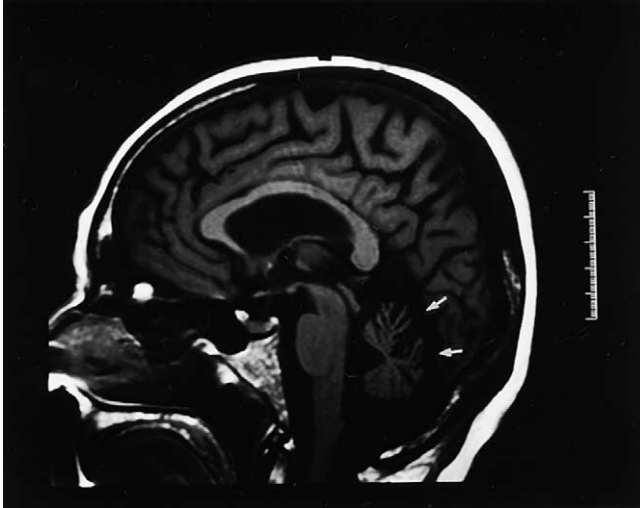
Sagittal T1-weighted MRI of the brain showing severe cerebellar atrophy in a 66-year-old woman who received high-dose cytosine arabinoside for acute myelogenous leukemia 10 years previously. During her consolidation therapy with cytosine arabinoside she developed severe dysarthria and ataxia. These symptoms improved over the next few months but her speech and balance never returned to normal.
